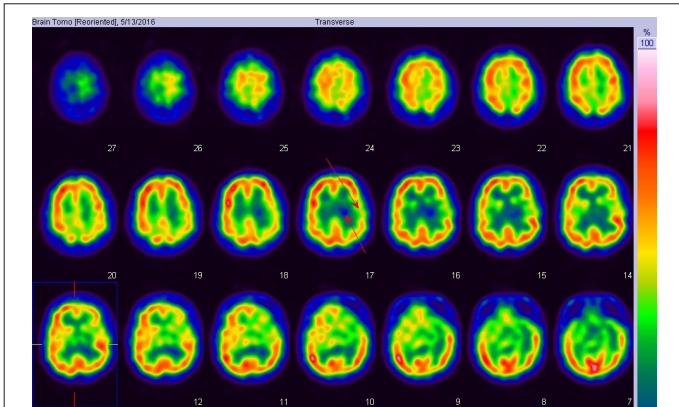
SPECT transverse section image shows a radiotracer defect in the left basal ganglia and corona radiata; reduced cerebral blood flow perfusion the left parietal and temporal lobes.
